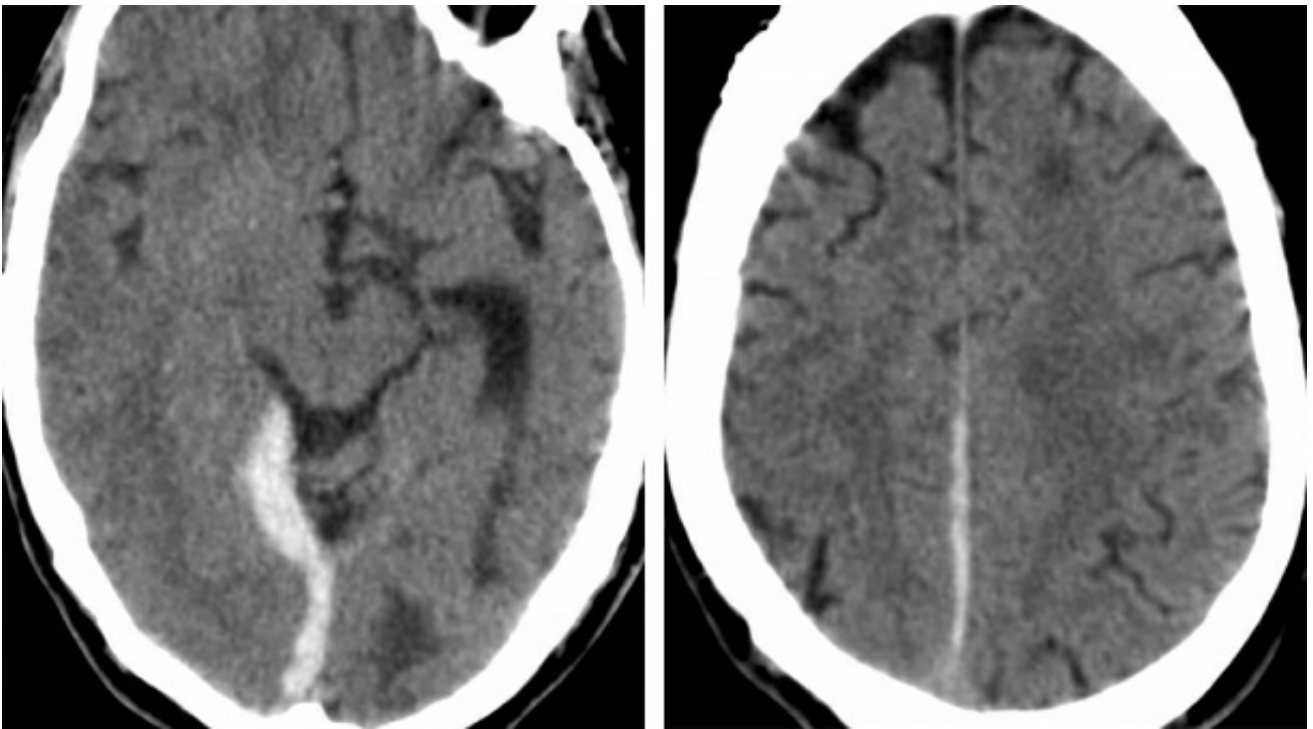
The acute posttraumatic subdural hematoma in this patient is seen on CT along the right tentorial leaf (left) and along the posterior aspect of the falx (right). Careful attention to the density and thickness of the falx can aid in detection of even very thin hematomas that may have prognostic implications in an otherwise normal study. Calcifications along the falx may have a similar appearance but are usually less dense.
